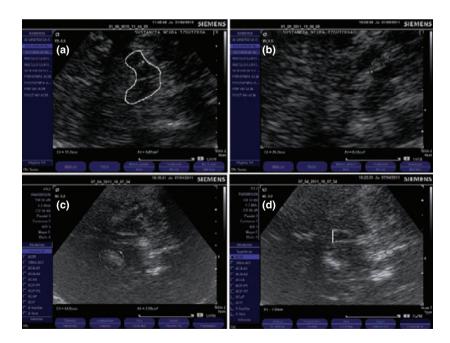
Transcranial sonography in patients with drug-induced parkinsonism. (A) Midbrain (delimited by a thick line) and substantia nigra (delimited by a fine line) of a patient with iatrogenic parkinsonism. (B) Hyperechogenic substantia nigra (delimited by a continuous line) in a patient with idiopathic Parkinson's disease. (C) Hyperechogenic contralateral lentiform nucleus (delimited by a continuous line) in a patient with subclinical drug-exacerbated parkinsonism. (D) Dilated third ventricle in a patient with iatrogenic parkinsonism.
